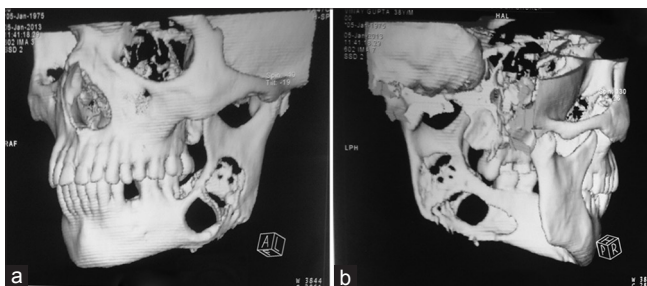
(a) Three-dimensional computed tomography image showing a large osteolytic lesion with erosion of buccal cortex. (b) Three-dimensional computed tomography image showing a large osteolytic lesion with erosion of lingual cortex
